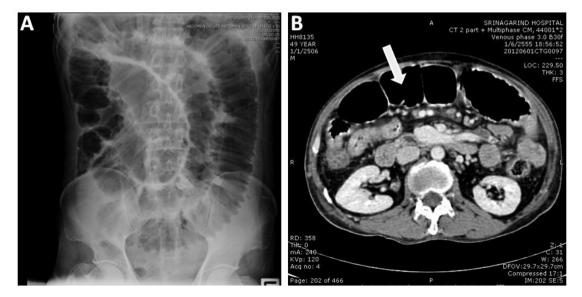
Acute abdomen supine x-ray film (A) revealed abrupt change in caliber and a fluid filled loop of the small intestine, thought to be the distal ileum. Multiple mesenteric lymph node enlargements were seen with some ascites. In panel B, showing axial computerized tomography scan of upper abdomen revealed abrupt change in caliber and a fluid-filled loop of the small intestine, thought to be the distal ileum. Multiple mesenteric lymph node enlargements were seen with minimal ascites. Arrow indicates transitional zone of small bowel dilatation at distal ileum.
